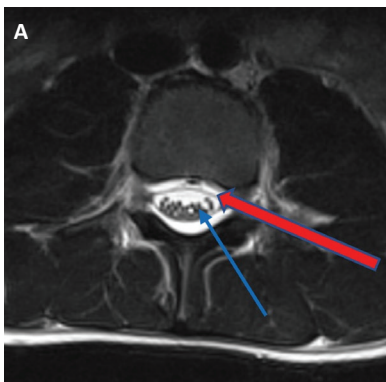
A: Axial T2 MRI, B: Sagittal T2 MRI, lumbar region, shows that extradural CSF accumulation (12 hours after lumbar puncture). Red arrow shows dura mater, blue arrow shows epidural space. C: Axial T2 MRI, normal lumbar region in different child (for comparison)
